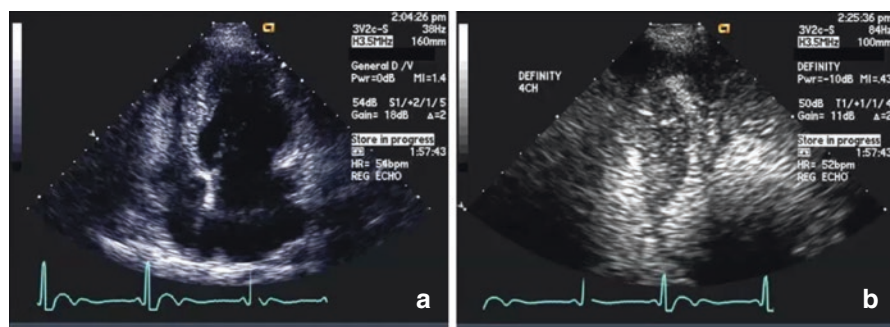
Side-by-side comparison of the unenhanced (a) and contrast-enhanced (b) apical four-chamber view. Improved delineation of the endocardium helps demonstrate mid-cavitary obliteration from touching of the anterolateral and the infero-septal walls
